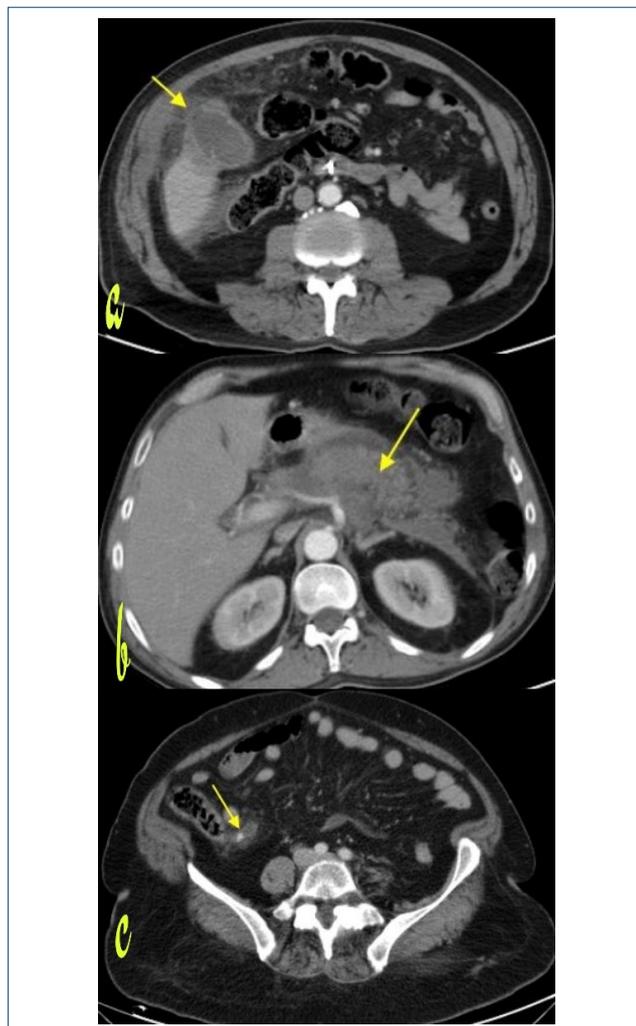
Computed tomography images of the patients with gallbladder perforation showing irregularity in the wall of the sac and adjacent fat stranding (a); with pancreatitis showing an increase in thickness and adjacent fat stranding (b); and with appendicitis showing an increase in the diameter, edema in the wall, intraluminal appendicoliths, and adjacent fat stranding (c).
